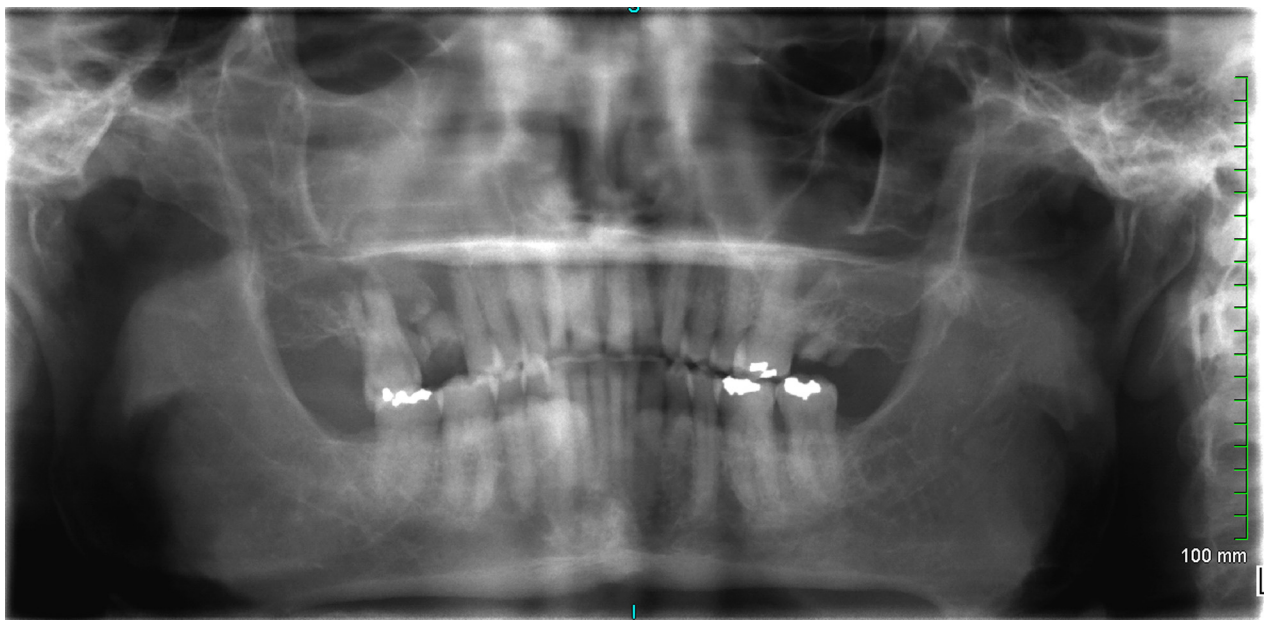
Panorex radiograph.
